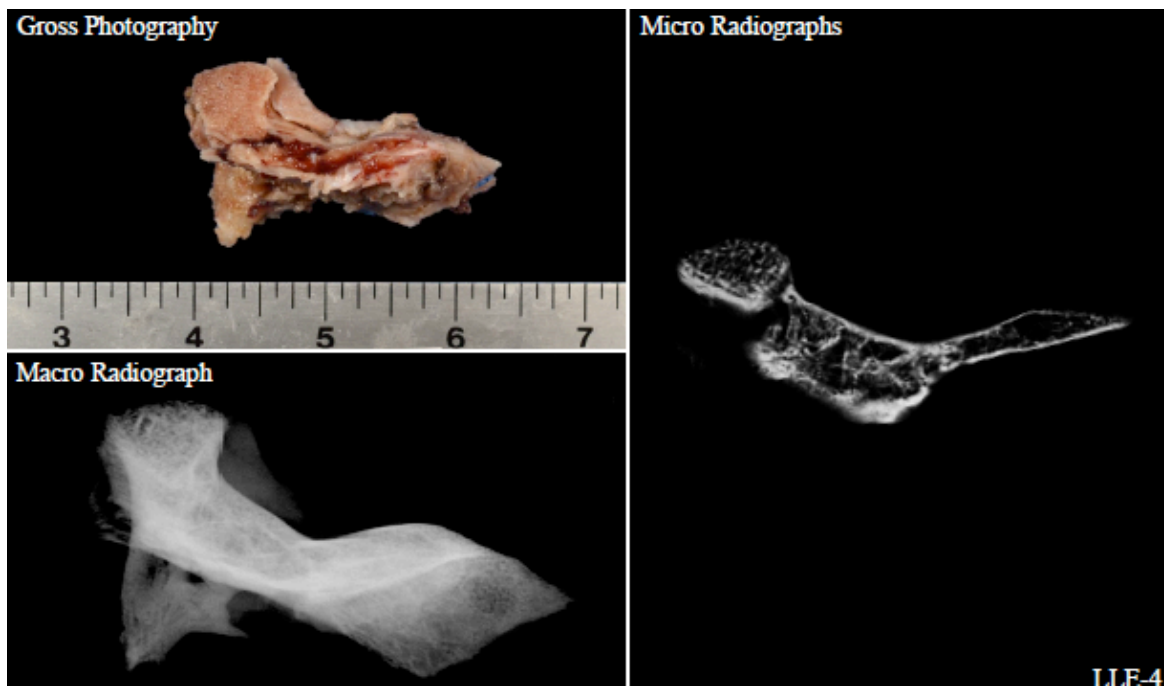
Gross photography and micro/macro radiography from one of the bone samples removed from the wounded warriors included in this study. Note that there is a combination of cortical and trabecular bone (as demonstrated in the microradiograph).
